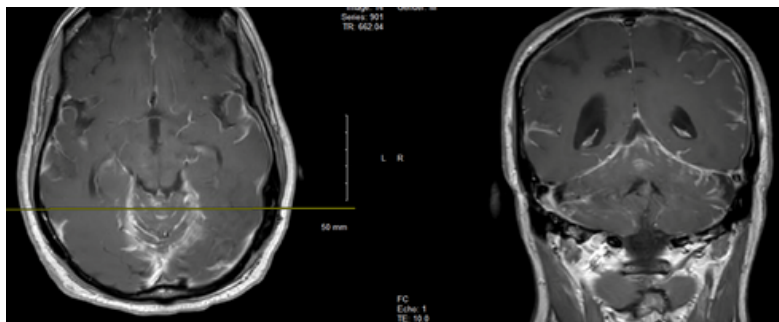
MRI brain w/wo (T1 post axial, T1 post coronal)
